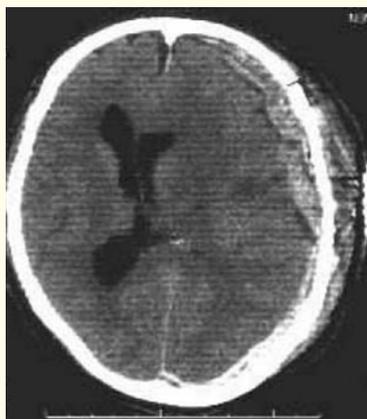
CT of an acute subdural hematoma (ASDH) as a impediment of a craniotomy.
